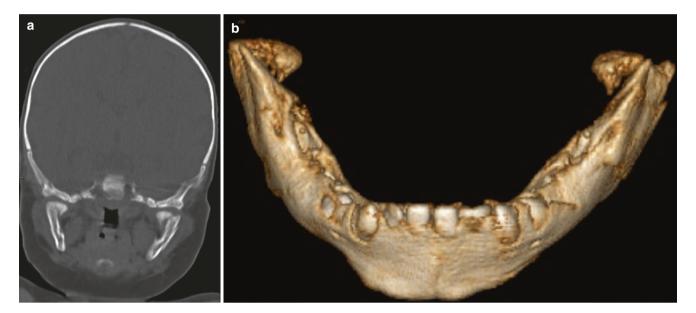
A 5-month-old Infant who underwent a non-accidental injury workup because of facial bruises after a fall. (a) Bilateral condylar fractures are seen on coronal CT reconstructions. (b) 3D rendering of the fractures
